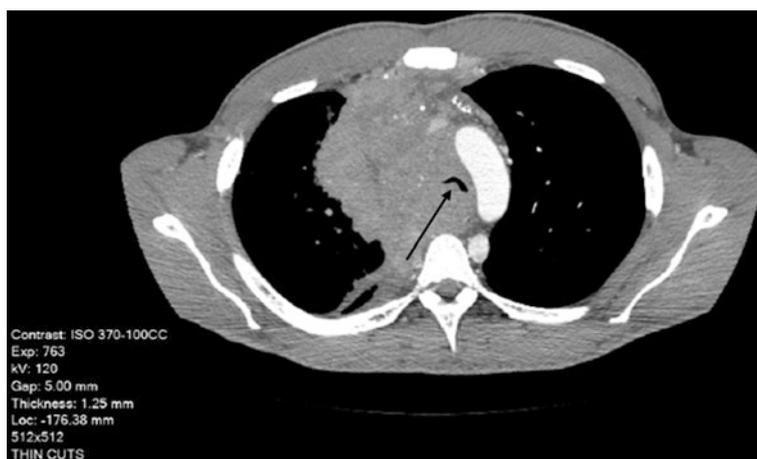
CT showing mediastinal mass causing deviation and crescentic compression of the trachea
